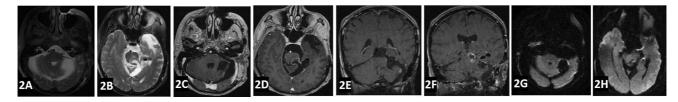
Immediate postsurgery magnetic resonance imaging (MRI). (A, B) Axial T2-weighted MRI. Axial (C, D) and coronal (E, F) MRI and axial diffusion-weighted imaging (G, H) revealed microsurgical gross total resection of both components of the mass.
